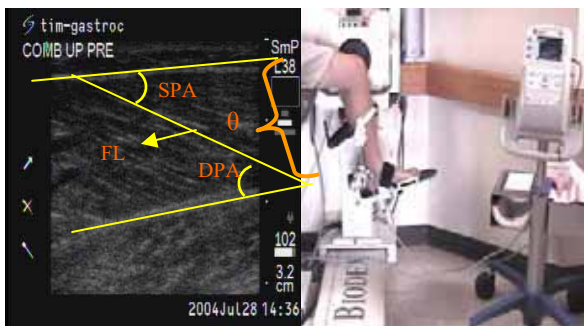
A) Ultrasound image with angles to calculate: SPA, IPA, and θ . B) Biodex and Linear actuator, with custom foot plate to move the knee and ankle.
